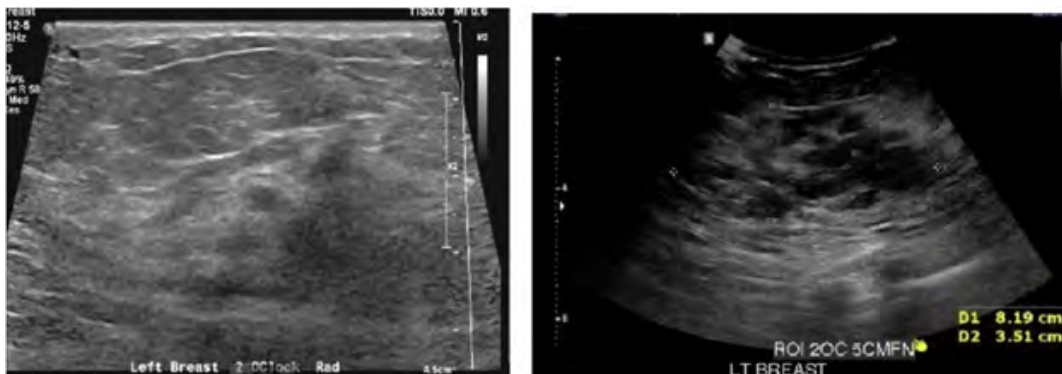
Showing left breast lesion while first referred by GP and repeat ultrasound after review in clinic for progress.
